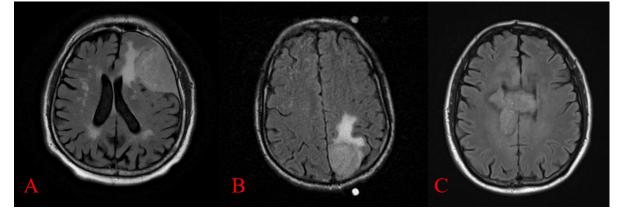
MRI scans of: A) typical meningioma, B) anaplastic meningioma, and C) glioblastoma. *Note that these are just one example of each type and does not represent all meningiomas or glioblastomas.
